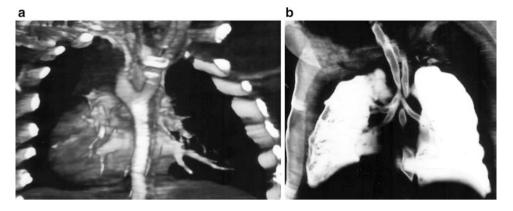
Enhanced computed tomographic images of (a) double aortic arch surrounding the trachea and the esophagus causing (b) severe narrowing of the distal trachea
